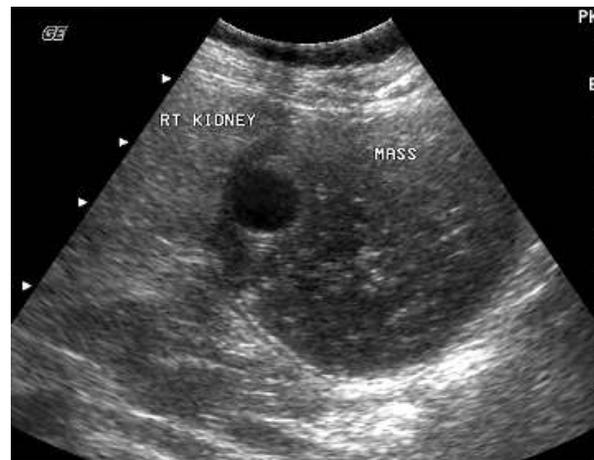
Ultrasound picture of the mass in upper pole of right kidney
